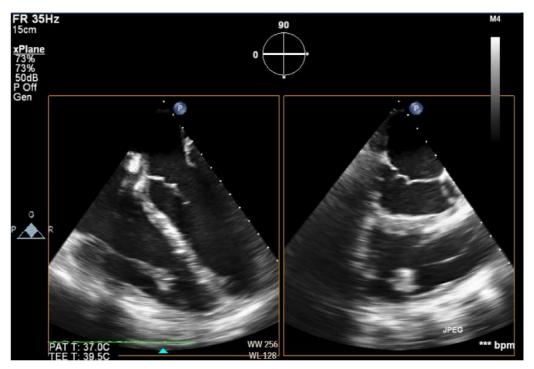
Transesophageal echocardiographic image showing small thrombus present on the tip of the pulmonary artery catheter.
